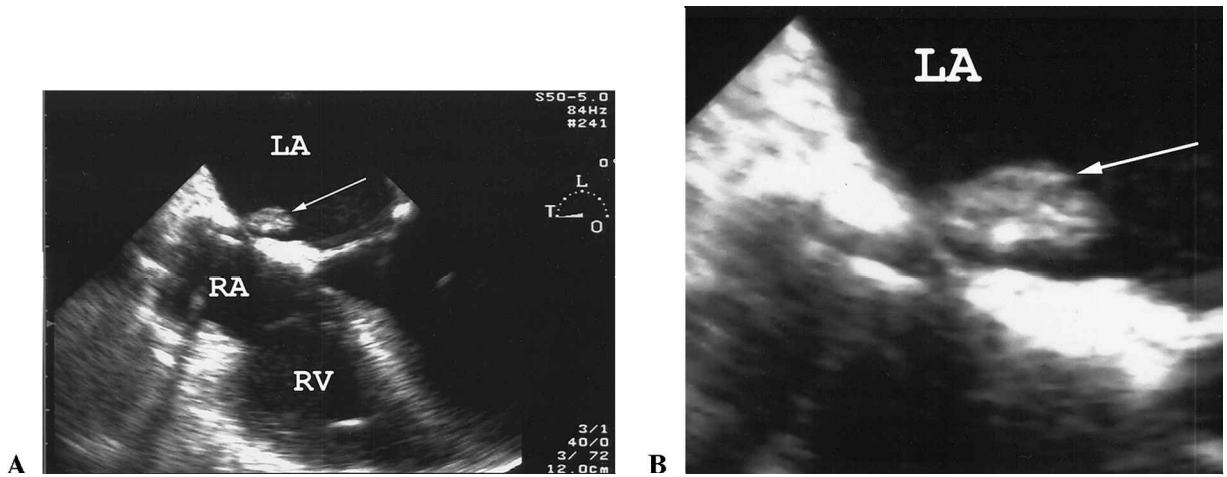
A. TEE image in the horizontal plane demonstrating a mobile mass attached to the left atrial side of the interatrial septum. B. Close-up image suggests a heterogeneous appearance of the atrial septal mass. TEE = transesophageal echocardiography.
